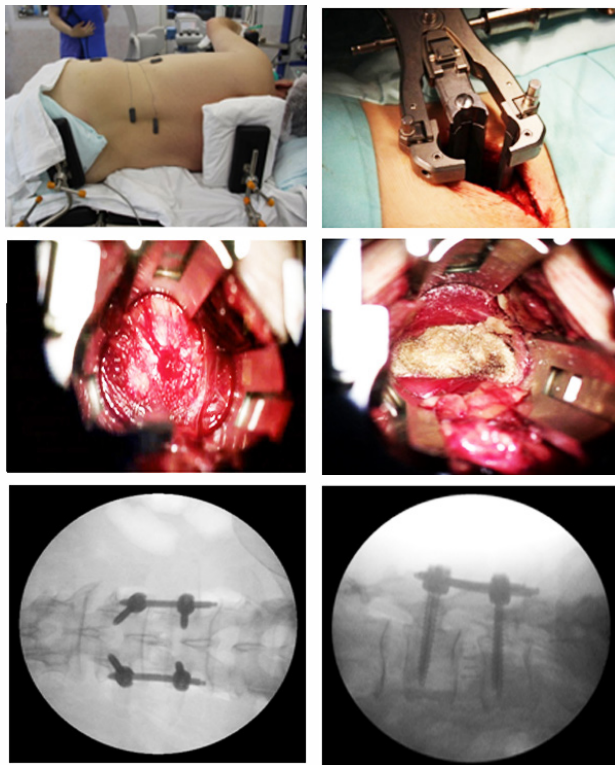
Intraoperative images: (A) – position of the patient on the operating table; (B) – installation of Oracle retractor; (C) – type of surgical wound with visualization of the front and middle parts of L_{III} - L_{IV} intervertebral disc; (D) – view of the surgical wound after discectomy, cage installation and laying of hemostatic material. X-ray position control of design elements using electrooptical converter; (E) – in frontal projection; (F) – in lateral projection
